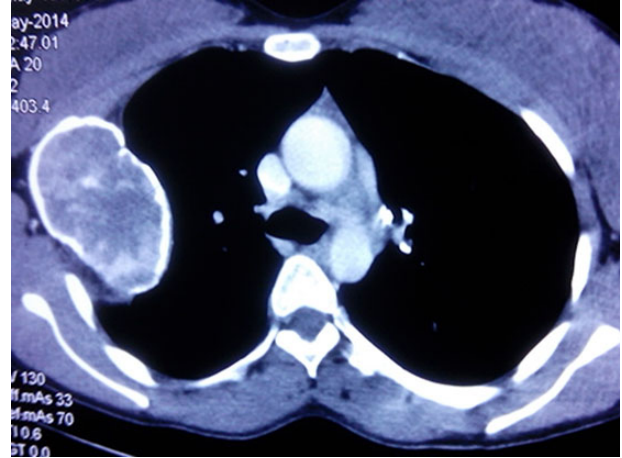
CT scan showing a well-defined expansile lytic lesion with a heterogeneous pattern of enhancement with ground-glass matrix and with a thick sclerotic margin extending along the length of anterolateral aspect of the second rib on the right side.
